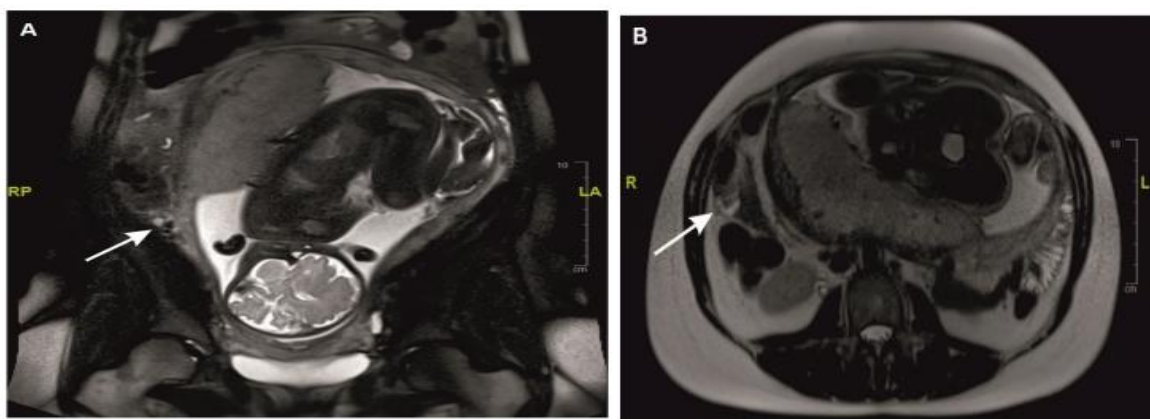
MRI showing small margin of free peritoneal fluid found at presumed base of appendix
